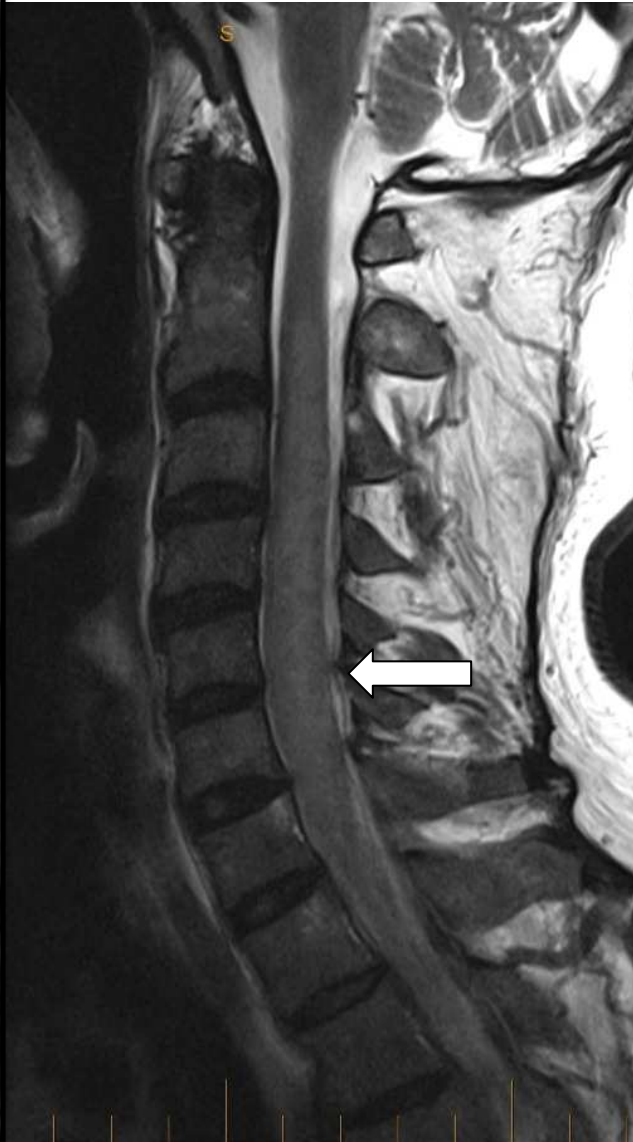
Magnetic Resonance Imaging of cervical spinal cord in a patient with chronic lymphocytic leukaemia (A) at the time of cervical myelopathy diagnosis; (B) after failed corticosteroid therapy; and (C) after 5 months of ibrutinib therapy.
